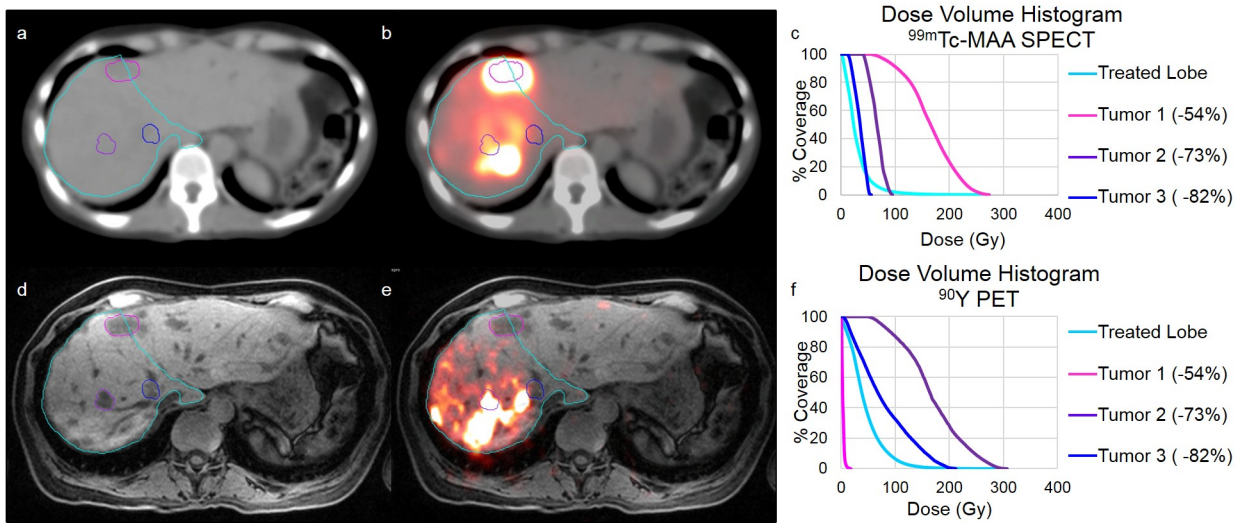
48-yr old female with metastatic pancreatic cancer treated with hepatic radioembolization of  $^{90}\text{Y}$  resin microspheres to the right lobe. (a-b) Pre-treatment  $^{99m}\text{Tc-MAA}$  SPECT/CT and (c) associated dose volume histogram. (d-e) Post-treatment  $^{90}\text{Y}$  PET/MRI and (f) associated dose volume histogram. Percentages in legend indicate the change in lesion volume from radioembolization to follow-up imaging (94 days). Tumor 1 showed a much higher uptake of  $^{99m}\text{Tc-MAA}$  than  $^{90}\text{Y}$ , whereas Tumors 2 and 3 showed much higher uptakes of  $^{90}\text{Y}$  than  $^{99m}\text{Tc-MAA}$ .
